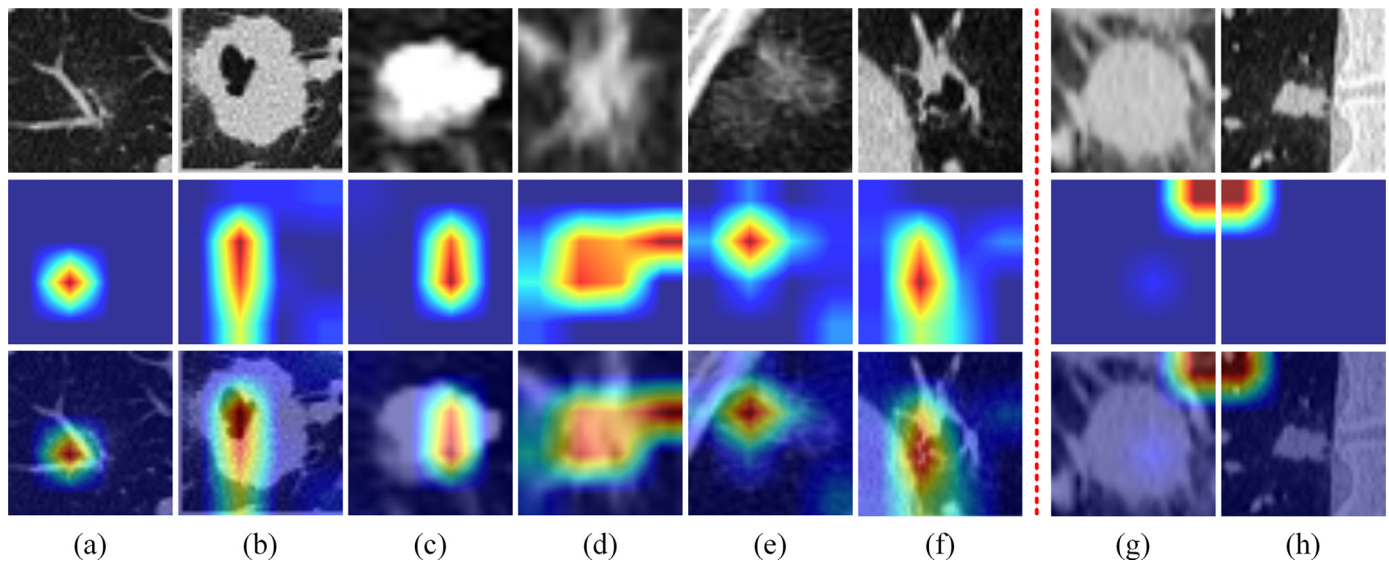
Visualization of pulmonary nodules and the corresponding CAMs. Top row are original CT images of pulmonary nodules, middle row are CAMs, and bottom row are images obtained by superimposing CAMs on corresponding CT images of pulmonary nodules. In Fig. 8, we visualized the pulmonary nodules that Mr-Mc predicts correctly ((a)-(f)) and the pulmonary nodules that predict incorrectly ((g), (h)). Note that you can find CAM visualization images of all pulmonary nodules in the test set at the following website: <https://github.com/fuyu-sdu/CAM-visualization-data/blob/main/CAM.zip>. (For interpretation of the references to colour in this figure legend, the reader is referred to the web version of this article.)
